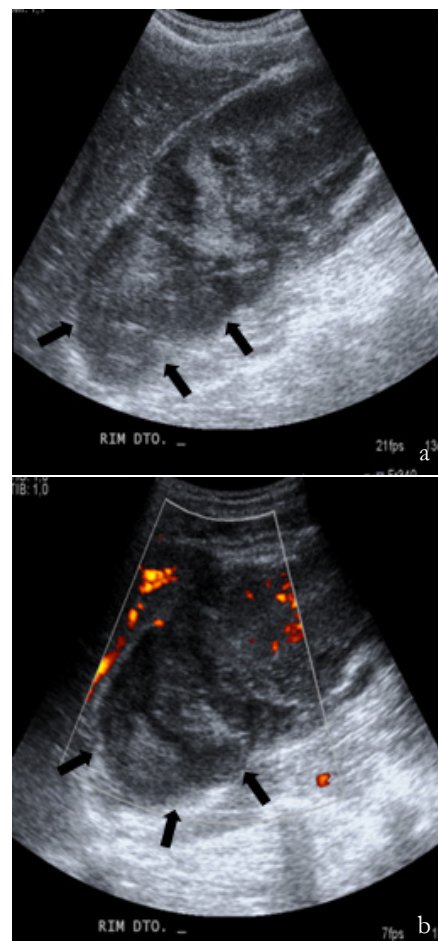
a) and b) - Doppler US. Peri-renal hematoma (arrows) with no vascular flow in the upper third of right kidney.
